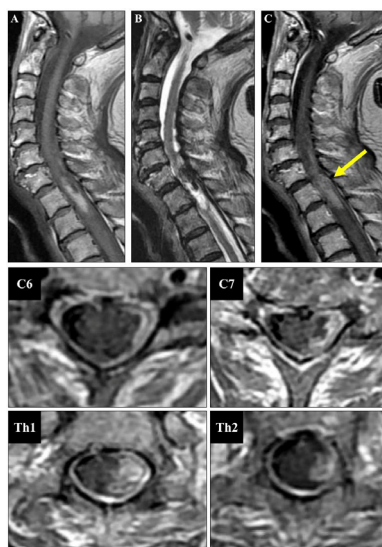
Sagittal magnetic resonance imaging (MRI) of the cervicothoracic spine show hyper- and hypointense masses in the subdural space on T1 (A) and T2 (B) images. Gd T1-enhanced MRI (C) showing partial enhancement (arrow). Axial MRI of the cervicothoracic spine at the C6 to Th2 levels shows a hyperintense mass in the left subdural space on the Gd-T1-weighted image.
